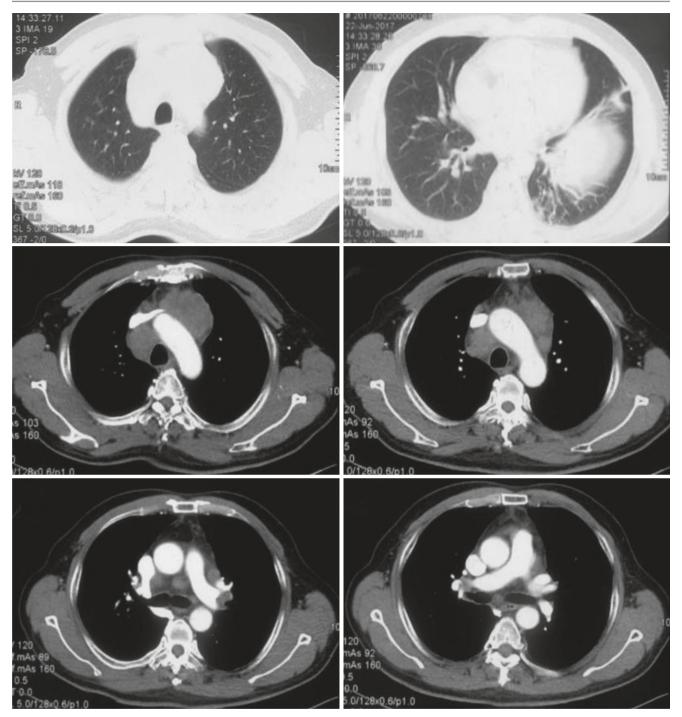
Chest CT images of a 59-year-old man were found to have enlarged left cervical lymph nodes for 12 days
